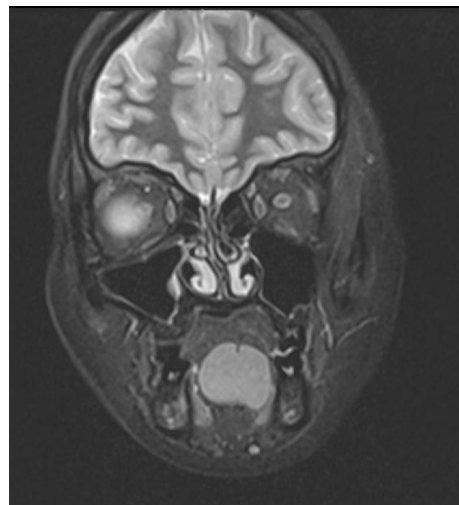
MRI head and neck shows features suggestive of ranula.
